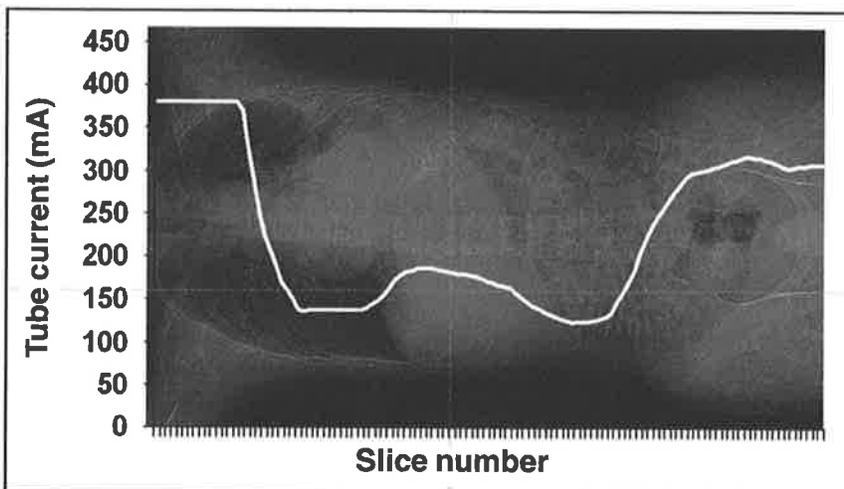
Tube currents delivered with automatic tube current modulation in an older teenager using a 16-slice CT scanner (LightSpeed CT scanner, GE Healthcare, Waukesha, WI), which modulates tube current along the z-axis (kVp 140, pitch 1.375:1, slice thickness 5 mm). Note the relatively higher tube currents through the shoulders and pelvis and the lower tube currents through the midthorax and lower abdomen.
